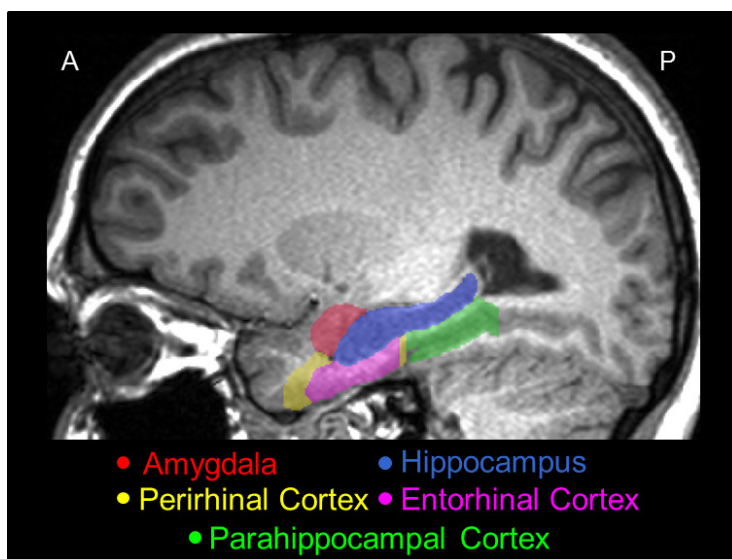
Sagittal slice of a structural MR image showing the medial temporal lobe, with delineations of the entorhinal cortex (pink), hippocampus (blue), perirhinal cortex (yellow), parahippocampal cortex (green) and amygdala (red). A = anterior, P = posterior. Reproduced with permission from [118].
